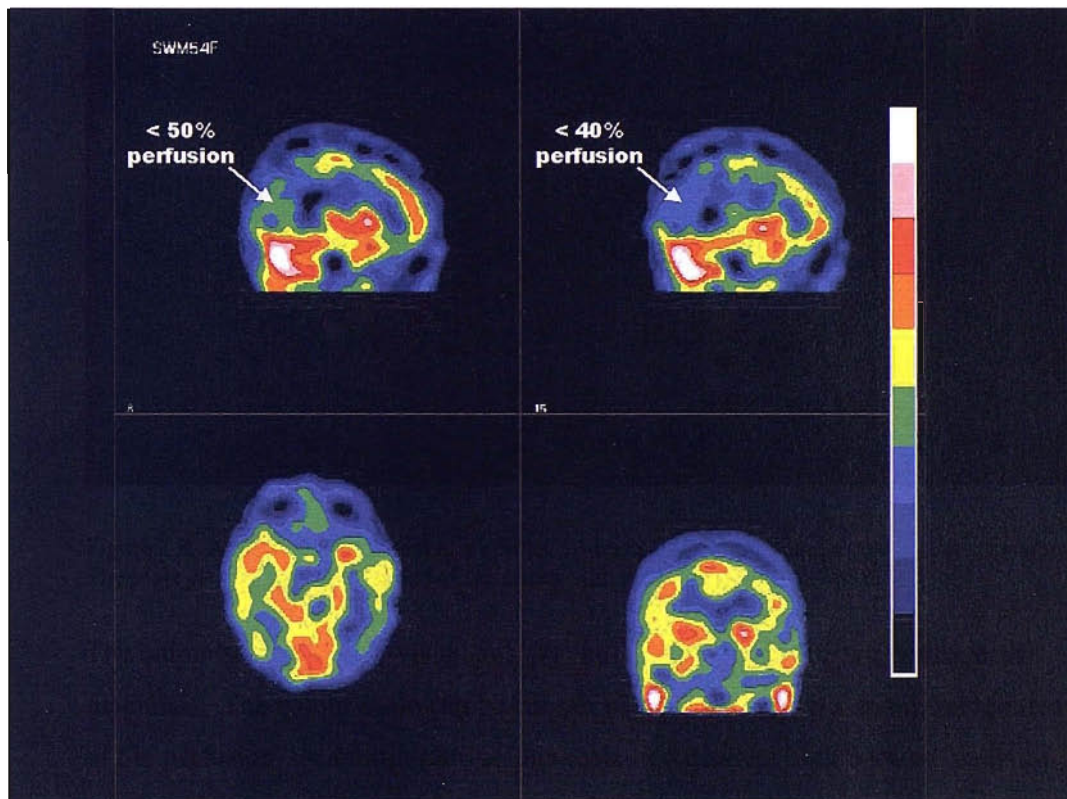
An example abnormal rCBF SPECT image of the brain using a quantitative colour scale. The scale clearly indicates regions of the cortex with abnormally low perfusion.
